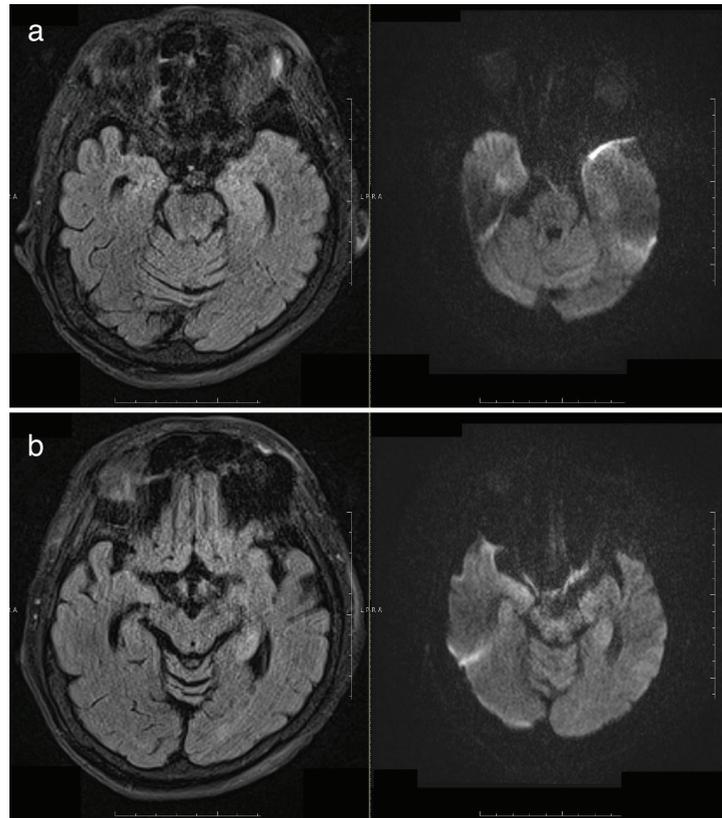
a, b) Cranial magnetic resonance imaging showing an increase in the T2A signal and an increase in volume at the left hippocampus and temporal lobe
